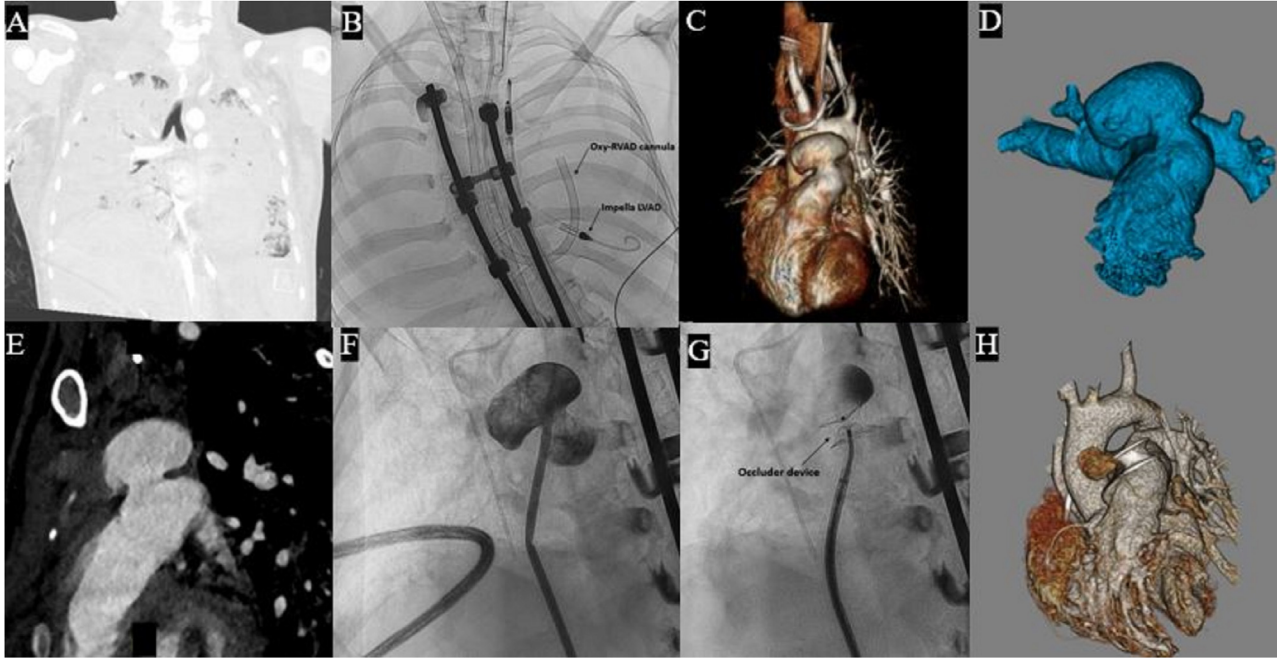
Rapidly enlarging pulmonary artery aneurysm and closure in a COVID-19 patient on cardio-respiratory support. (A) CT chest with COVID-19 ARDS, (B) Oxy-RVAD cannula in the main pulmonary artery and Impella LVAD in the left ventricle, (C and D) 3-dimensional reconstructed images showing the PA aneurysm, (E) CT slice showing PA aneurysm, (F) Angiogram with PA aneurysm pre-, (G) post-closure, (H) 3-dimensional reconstructed image showing minimal filling of closed PA aneurysm. CT, Computed Tomography; COVID-19, Coronavirus disease 2019; RVAD, Right Ventricular Assist Device; LVAD, Left Ventricular Assist Device; PA, Pulmonary Artery; LV, Left Ventricle.
